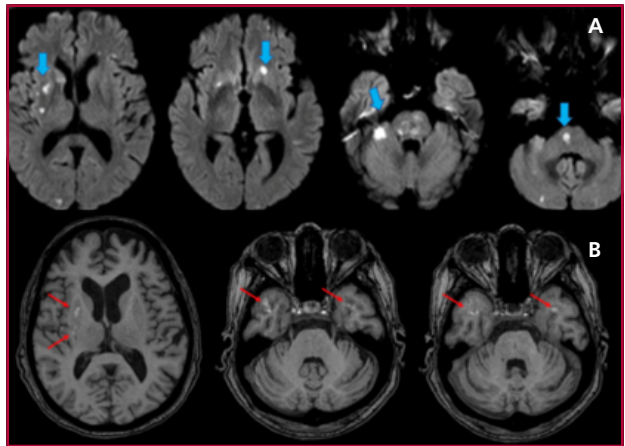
Brain Magnetic resonance imaging. A. Multiple signal changes in the pons, right cerebellar hemisphere, and subcortical white matter of both hemispheres; B. Hyperintense T1-weighted images in the putamen, right globus pallidus, and bilateral temporal lobe compatible with subacute bleeding
